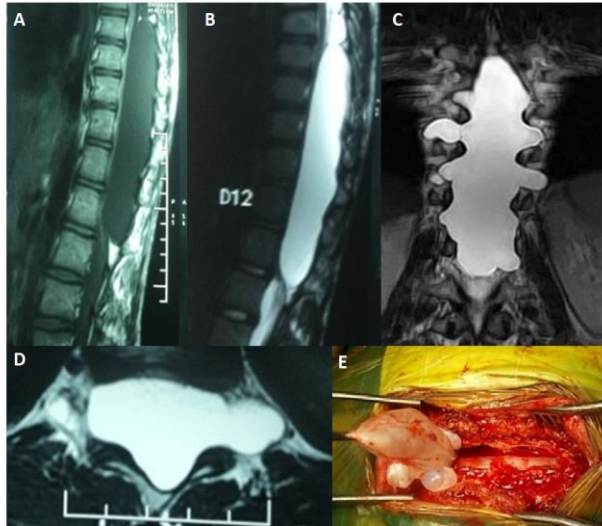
Extradural arachnoid cyst (case 1) extending from D8-L1. Sagittal T1 & T2 weighted (A, B) and coronal, axial T2W MRI images (C, D) demonstrating extension into neural foramina. Intra operative image (E) showing arachnoid cyst being excised and easily separable from underlying dura.
